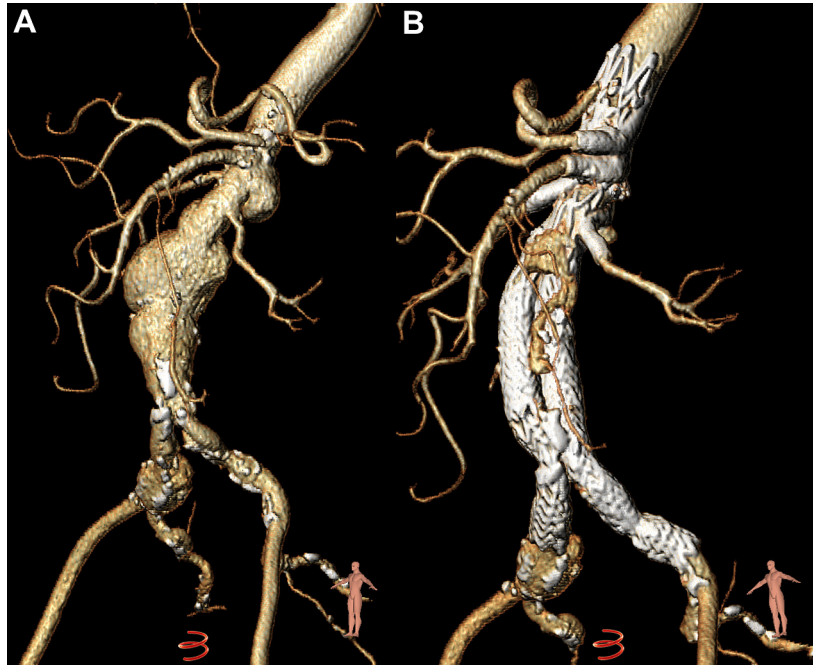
A, Preoperative computed tomography (CT) angiography reconstruction showing a suprarenal aneurysm, 6.3 cm in diameter. B, Postoperative CT angiography three-dimensional reconstruction showing total renovisceral revascularization with patent chimney grafts.
